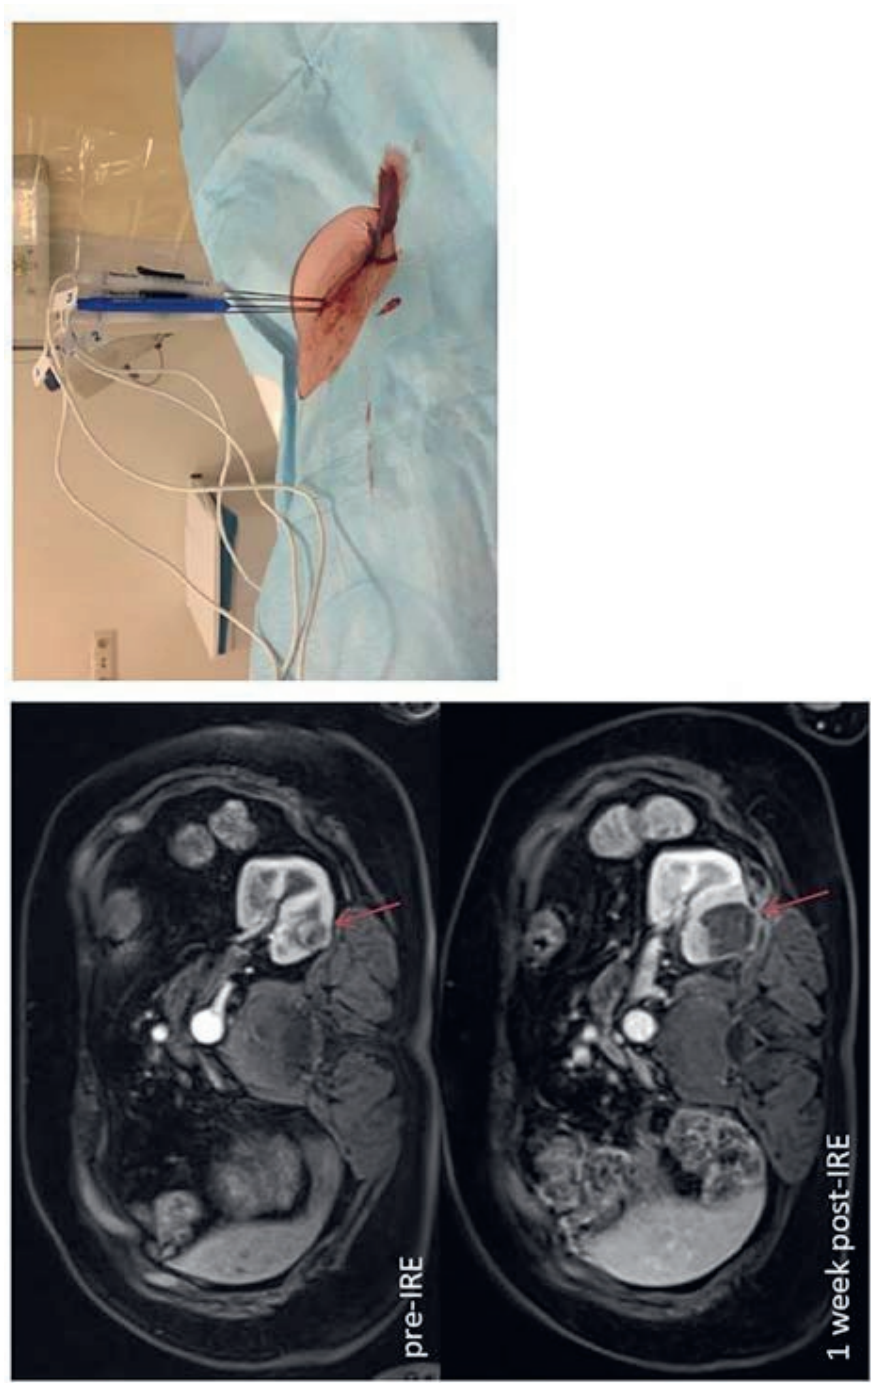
Left: MRI of pre-IRE tumour (red arrow), MRI and post-IRE ablation zone (red arrow). Right: Picture of IRE electrodes (blue and white) during the procedure. Note the sharp demarcation of the ablation zone. The operator percutaneously applies high Voltage to the tumour. IRE = irreversible electroporation.
